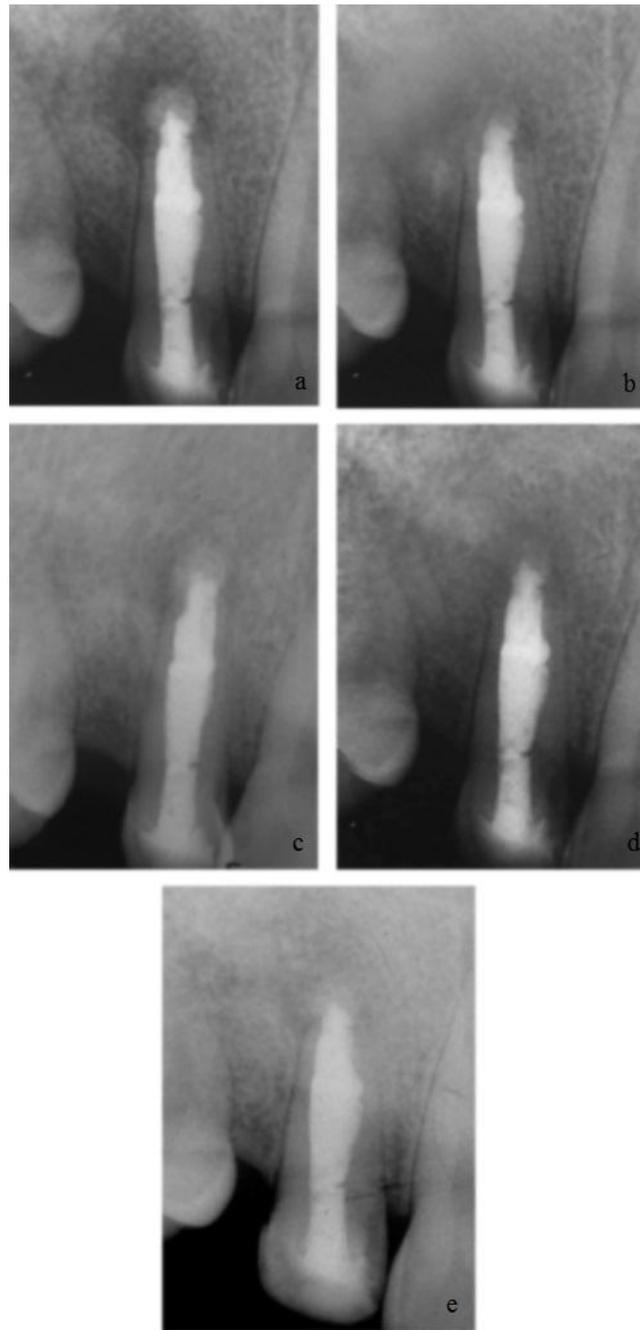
(a) Follow up radiography after 3 months; (b) after 6 months; (c) after 12 months and (d) after 18 months; (e) complete maturation of the apex and healing of the periapical bone were clearly seen.
